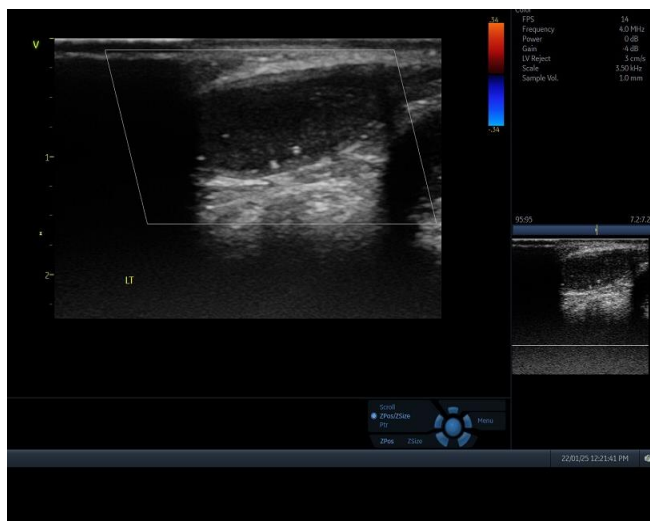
Longitudinal ultrasound showing testicular microlithiasis (classic) with multiple small punctate calcifications of varying sizes in the left testicular parenchyma.
